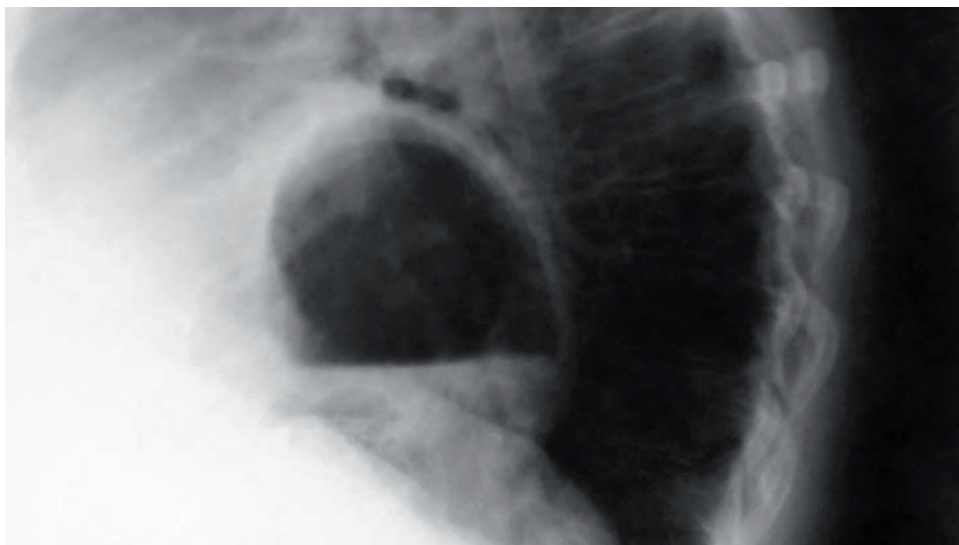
Chest radiograph of the upside-down stomach — lateral view.
